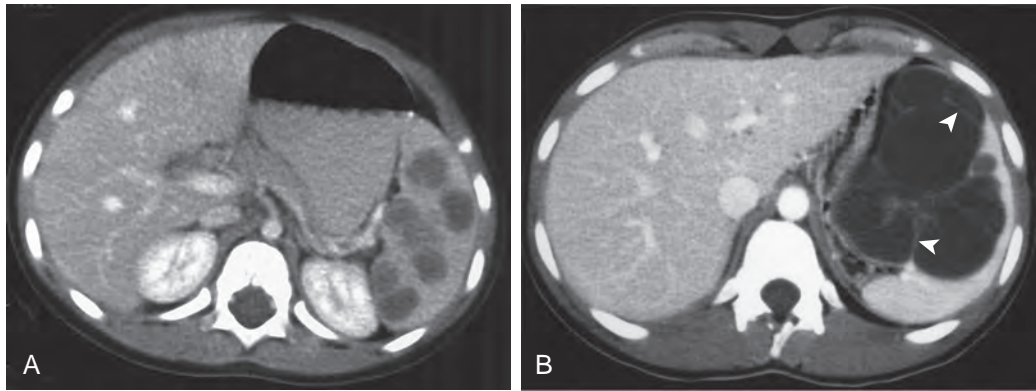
Lymphatic malformation. A. Multiple, nonenhancing, well-defined, low-attenuation, intrasplenic cystic lesions were incidentally found in a 3-year-old child. Lesions were stable during 1 month. Subsequent PET/CT examination showed no evidence of hypermetabolic features. Multiple lymphatic malformations were diagnosed at splenectomy. B. Contrast-enhanced CT in a different child demonstrates multiple septations (arrowheads) within this single, large lymphatic malformation that originates within the spleen. Although the septations may enhance, the cystic spaces of lymphatic malformations do not.
